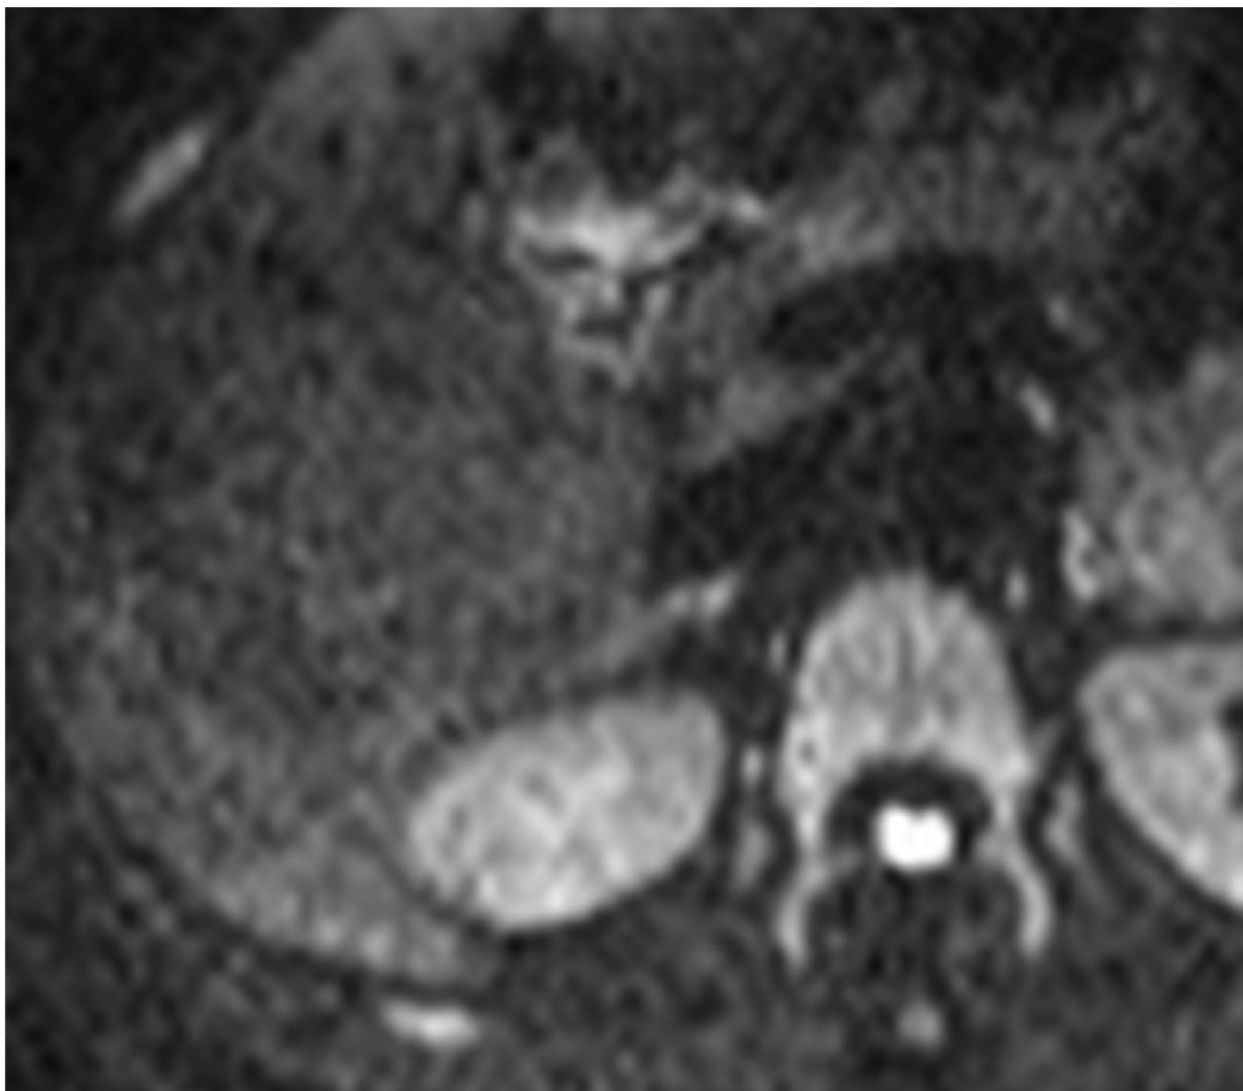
DW MRI. HA shows no restricted diffusion at b-value=800.
